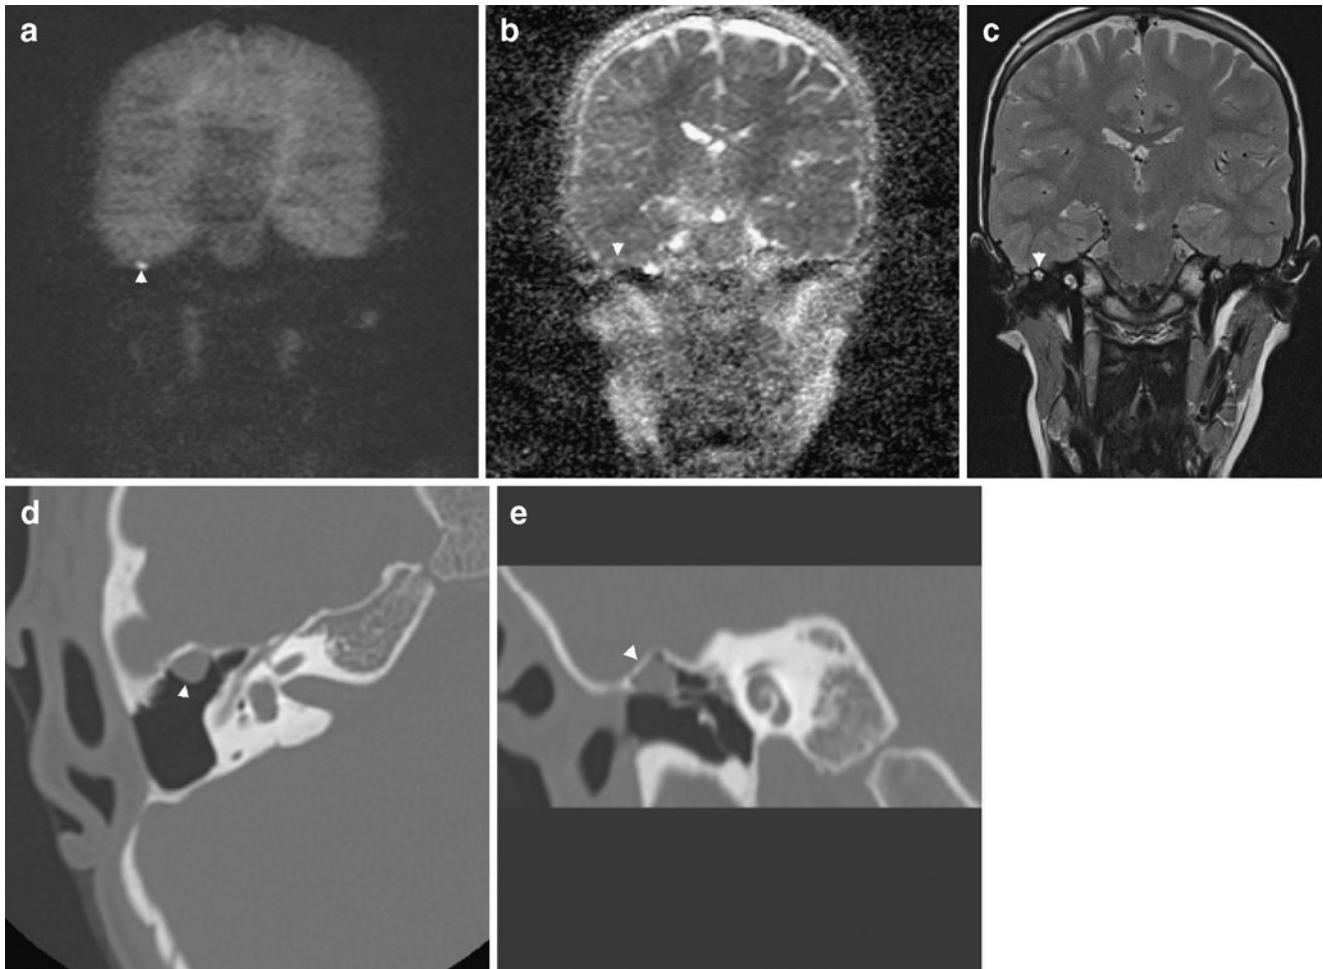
A 22-year-old-male with a history of cholesteatoma on the right side treated with canal wall up tympanoplasty 3 years before. At otoscopy, a whitish lesion was suspected at the upper limit of the tympanic membrane graft. Upon these clinical and otoscopic findings, MRI—using the non-EP DW protocol—was performed first. CT scanning was performed subsequently, based upon the MR findings. a The coronal non-EP DW b1000 image (SS TSE DW sequence or HASTE DW sequence) clearly shows a small nodular hyperintensity (*arrowhead*) immediately beneath the right temporal lobe. b On the coronal ADC map (same slice position as a), the lesion can be seen as a small nodular hypointensity (*arrowhead*) immediately beneath the right temporal lobe. c Coronal 2-mm-thick TSE T2-weighted image at the level of the cochlea (same level as a and b). The lesion is seen as a small nodule with moderate and high signal
